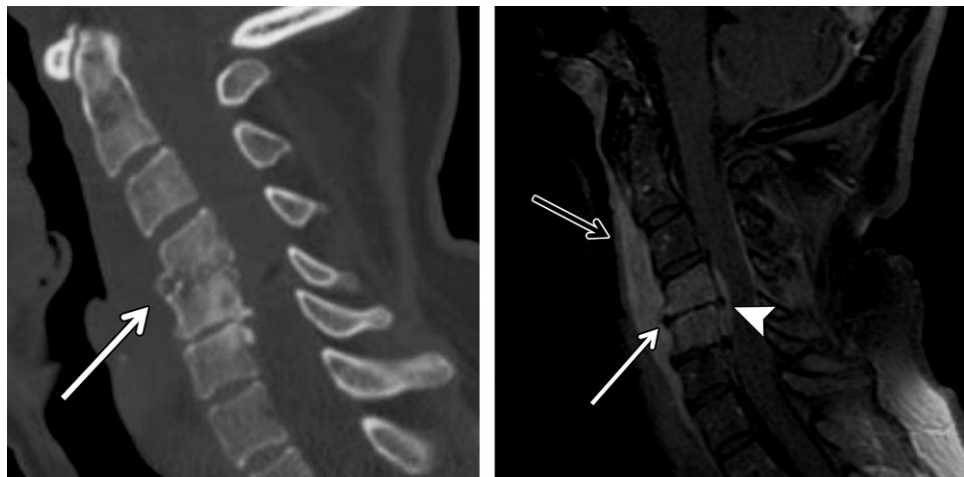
Discitis-osteomyelitis in a 55-year-old woman with a history of splenectomy who presented with 3 weeks of neck pain and tenderness in the right middle neck. Sagittal CT (a) and sagittal contrast-enhanced fat-suppressed T1-weighted MR (b) images show loss of disk height and endplate irregularities that involve two adjacent vertebral bodies (white arrow) with prevertebral (black arrow in b) and epidural (arrowhead in b) soft-tissue inflammation and abscess.
